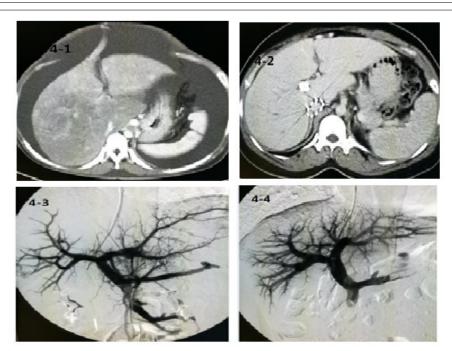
Imaging of a patient during follow-up protocol. A patient with SOS related hepatic cirrhosis that was reversed after TIPS treatment. Figure 4-1 shows preoperative CT shows reduced liver lobes and hepatic volume reduction. Figure 4-2 shows 2 years after TIPS treatment, liver CT scanning showed that the lobe of the liver increased, and the left lobe was markedly increased. Figure 4-3 shows a patient undergoing primary TIPS treatment portal vein angiography sparse branch of intrahepatic portal vein. Figure 4-4 shows 2 years after TIPS treatment, angiography showed shunt stent occlusion, development of the portal vein and its branches, and PSG decreased to normal level.
